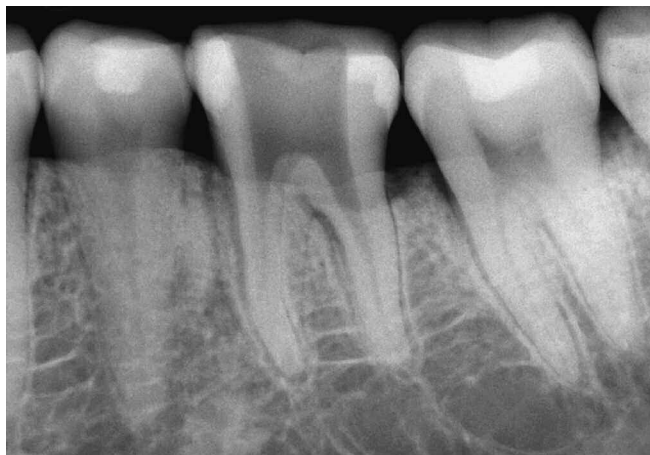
A radiograph confirms straightline access and the removal of the broken file.
